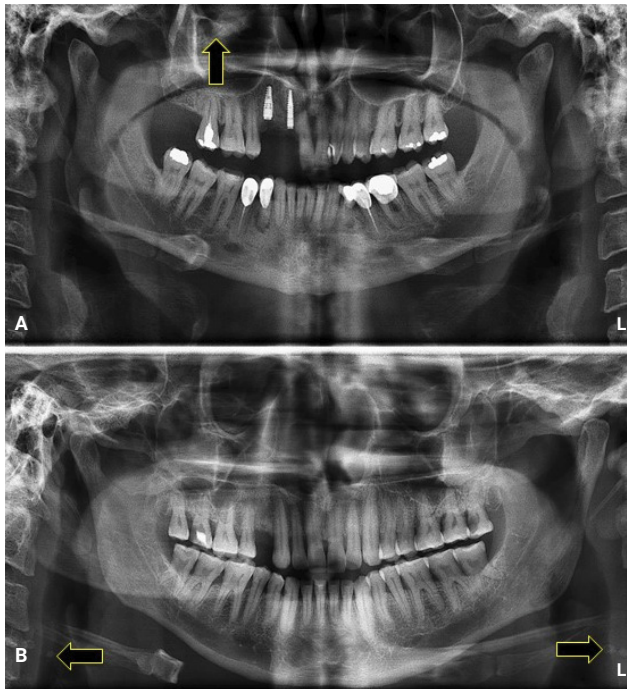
(A) The arrow on the panoramic radiograph showing a radiopaque mass in the right maxillary sinus suggestive of antrolith. (B) The arrows on the panoramic radiograph showing well-defined elongated radiopacity at the level of third cervical vertebrae suggestive of carotid artery calcification.
